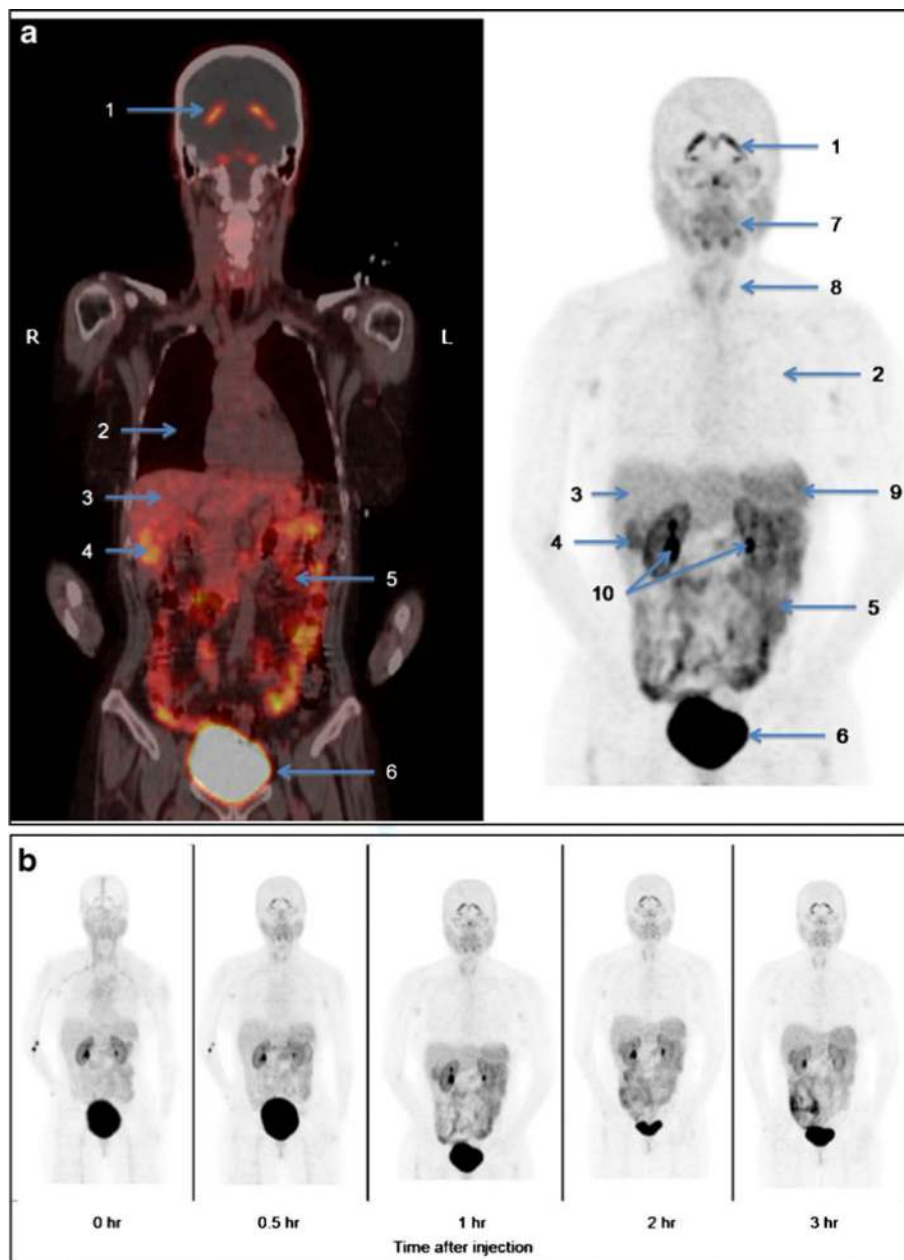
Clinical-grade [^{18}F]FPP(RGD) $_2$ (518 MBq/14 mCi) injected intravenously to a healthy human volunteer. Images include a coronal fusion PET/CT image (a, *left side*) and maximum intensity projection (MIP) image (a, *right side*) as well as serial MIP images (b). a was obtained 1-h post-injection and has the major organs of uptake labeled as follows: *1*, brain ventricles; *2*, lung; *3*, liver; *4*, gall bladder; *5*, bowel; *6*, urinary bladder; *7*, salivary glands/oropharynx; *8*, thyroid glands; *9*, spleen; and *10*, kidneys. The renal and hepatobiliary clearance routes of [^{18}F]FPP(RGD) $_2$ are evident. Above the diaphragm, there is only very limited uptake. The combined image in (b) shows the temporal stability of [^{18}F]FPP(RGD) $_2$ at five time-points post-injection.
